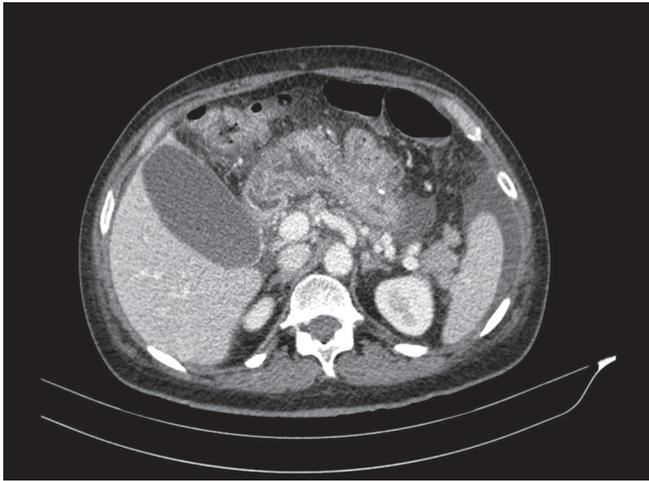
CT scan: Thickness of the anterior gastric antrum, fat stranding, small amount of free perisplenic fluid, and a millimetric bubble of free air
